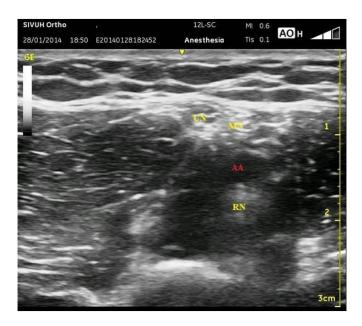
Arrow heads showing sonographic appearance of the conjoint tendon of the latissimus dorsi and teres major muscles
